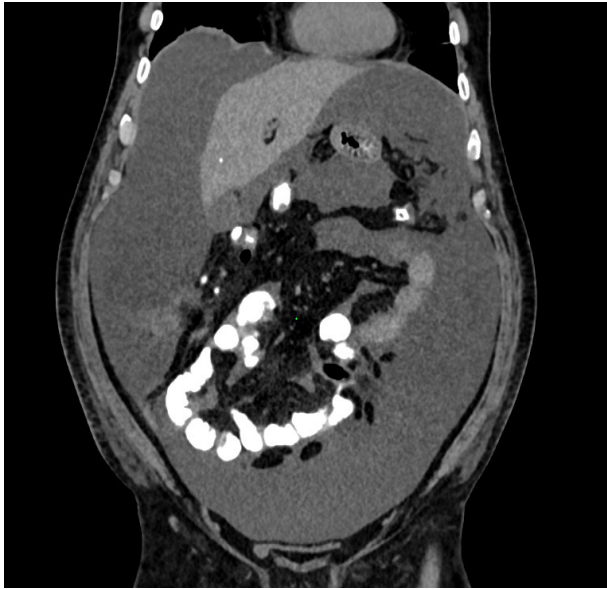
CT image of diffuse intraabdominal fluid in coronal section.
